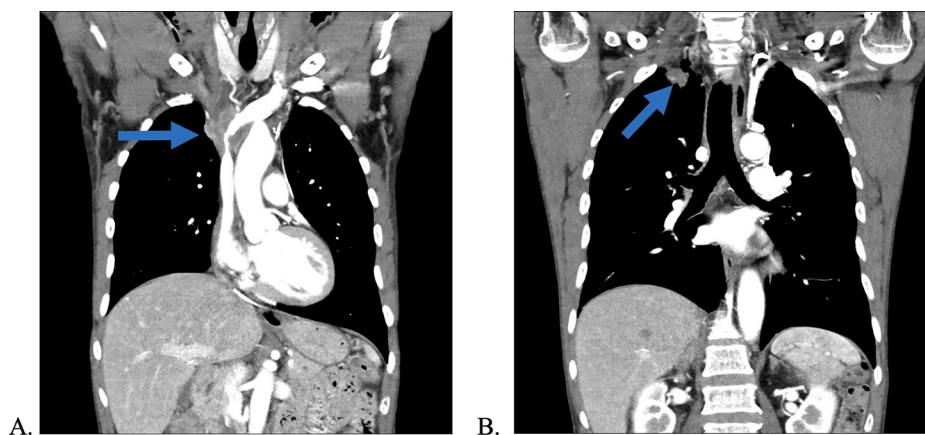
Computed tomography scan of the chest with i.v. contrast revealing (Panel A) a 4.5×2.0 -cm mass causing narrowing of the superior vena cava to 2 mm in diameter (arrow) and (Panel B) a 1.8×1.0 -cm spiculated mass in the right upper lobe of the lung (arrow).
